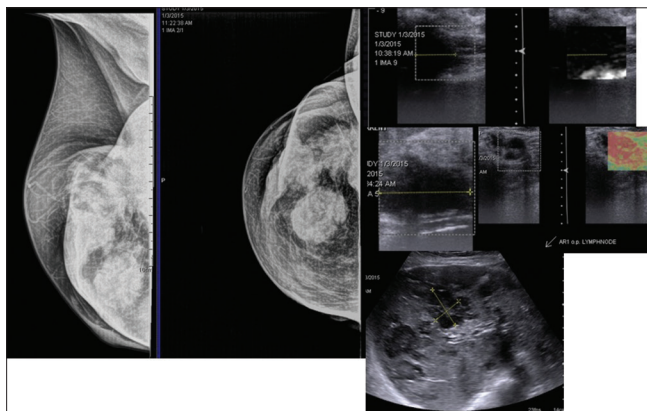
Mammography with sols and nipple deformation. Sonography showed masses with ill-defined margins, axillary lymph nodes and sols in liver.
